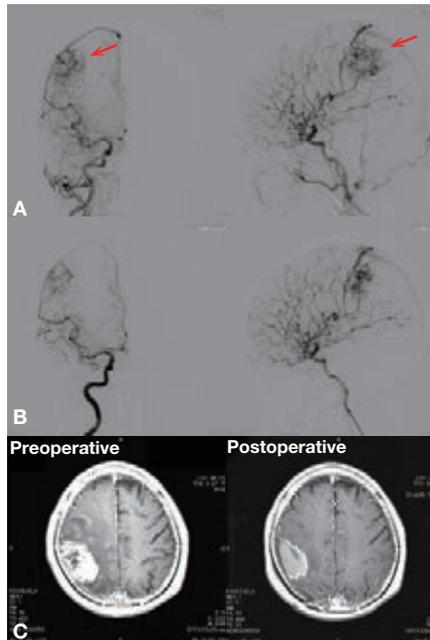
75-year-old woman with a right parietal tumor. (A) Right parietal tumor, (B) after TAE with NBCA, (C) preoperative and postoperative axial MR images.
